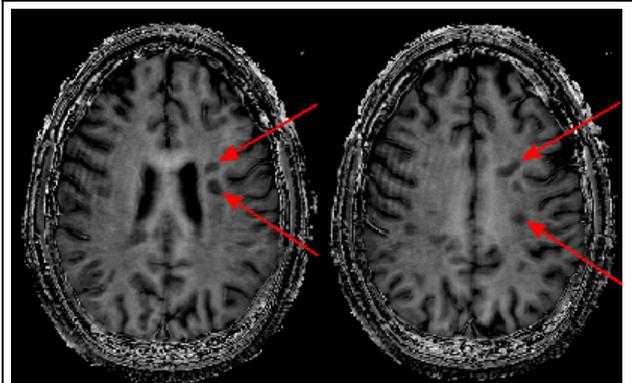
MTR-RAGE at 7T on a MS patient. Arrows indicates MS lesions that were also found T2-weighted images and T1 maps. The slice thickness was 1.5mm to allow a whole brain acquisition.
